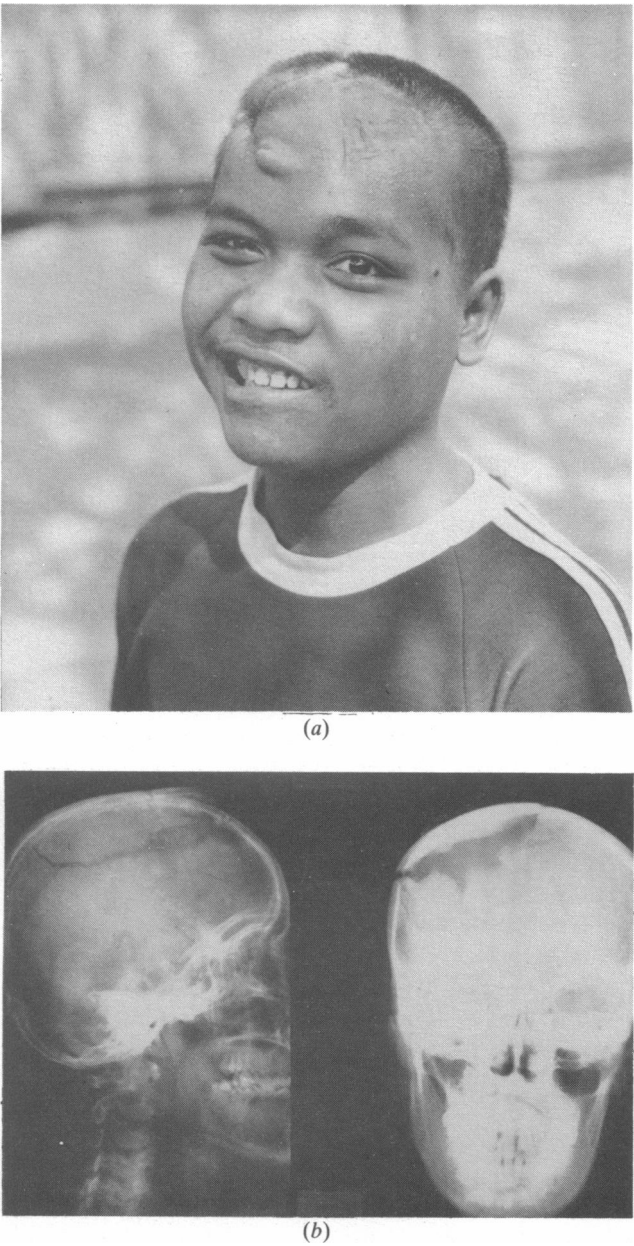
(a) A patient who received a tangential gunshot wound of the head. The exposed brain and bone defect were covered by a scalp transposition flap. Photograph taken 3 weeks after admission. (b) Skull radiographs of the patient shown in Fig. 1(a).
